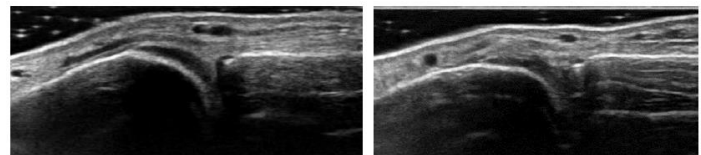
Alignment of metatarsophalangeal joints for ultrasound grading
